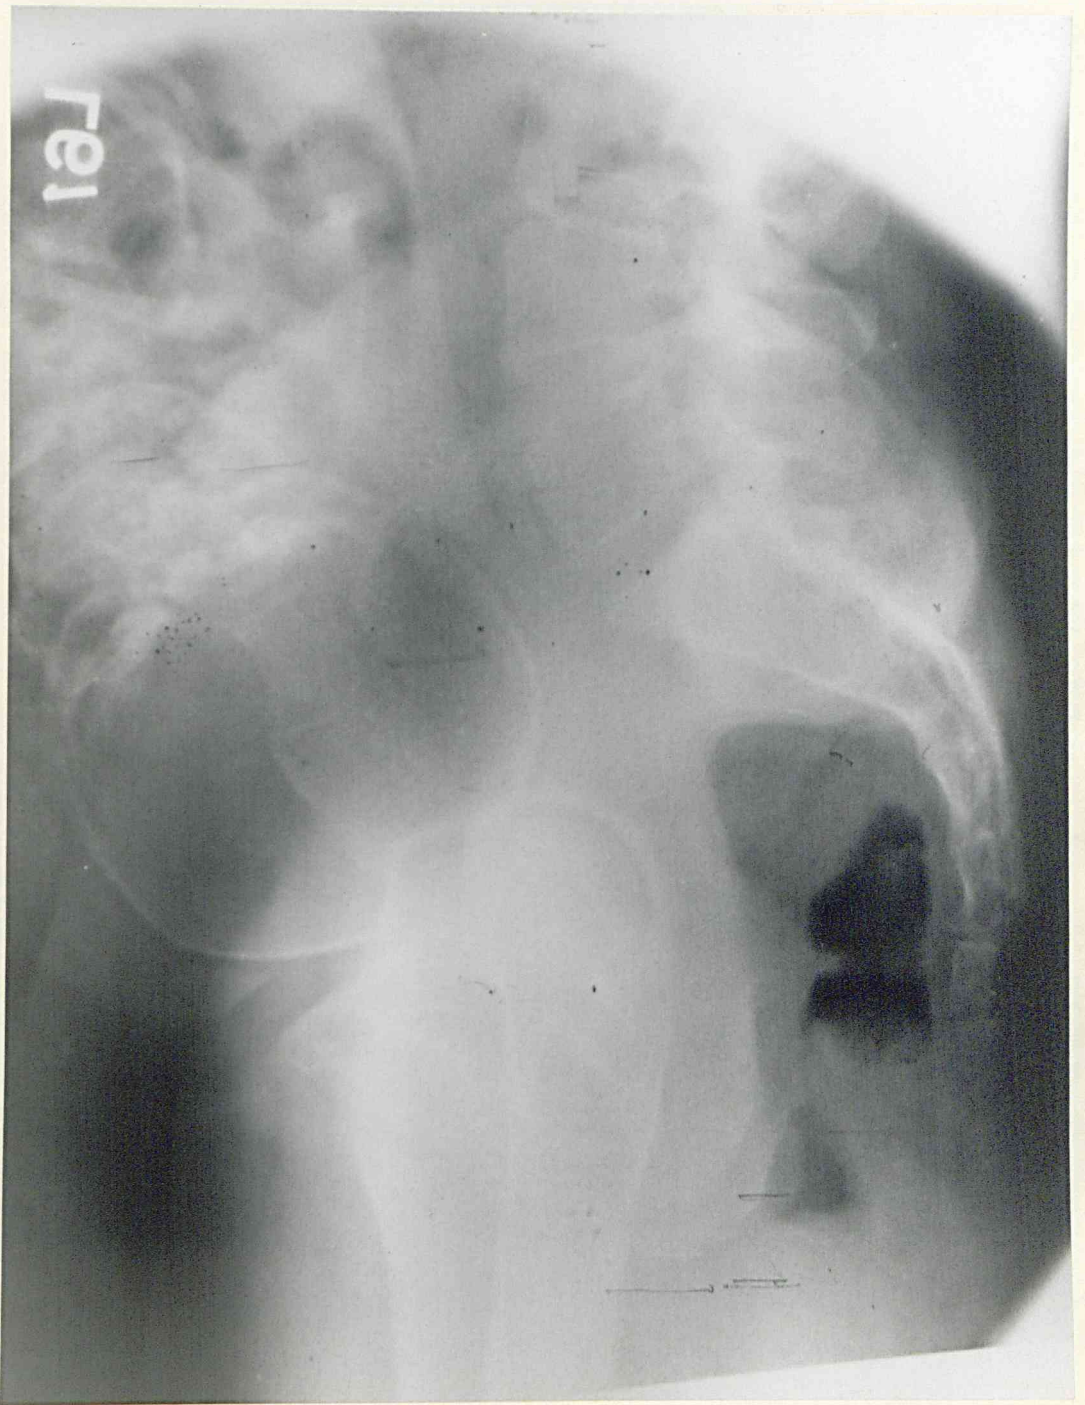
Erect lateral radiograph of the pelvis after amniography with 30 ml. of 70% Vasiodone. There is a greater amount of liquor anteriorly and the liquor is separated from the foetal skull by a black line due to the translucency of the subcutaneous tissues of its scalp. The film also shows how very thin the uterine wall is between the foetal head and the symphysis and promontory. (Case No. 290).
